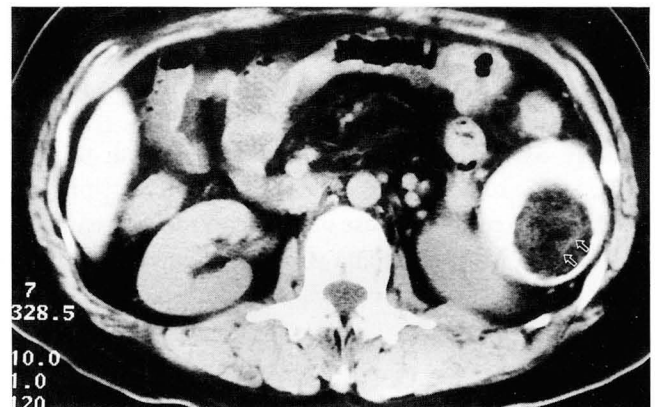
Postenhanced CT scan
